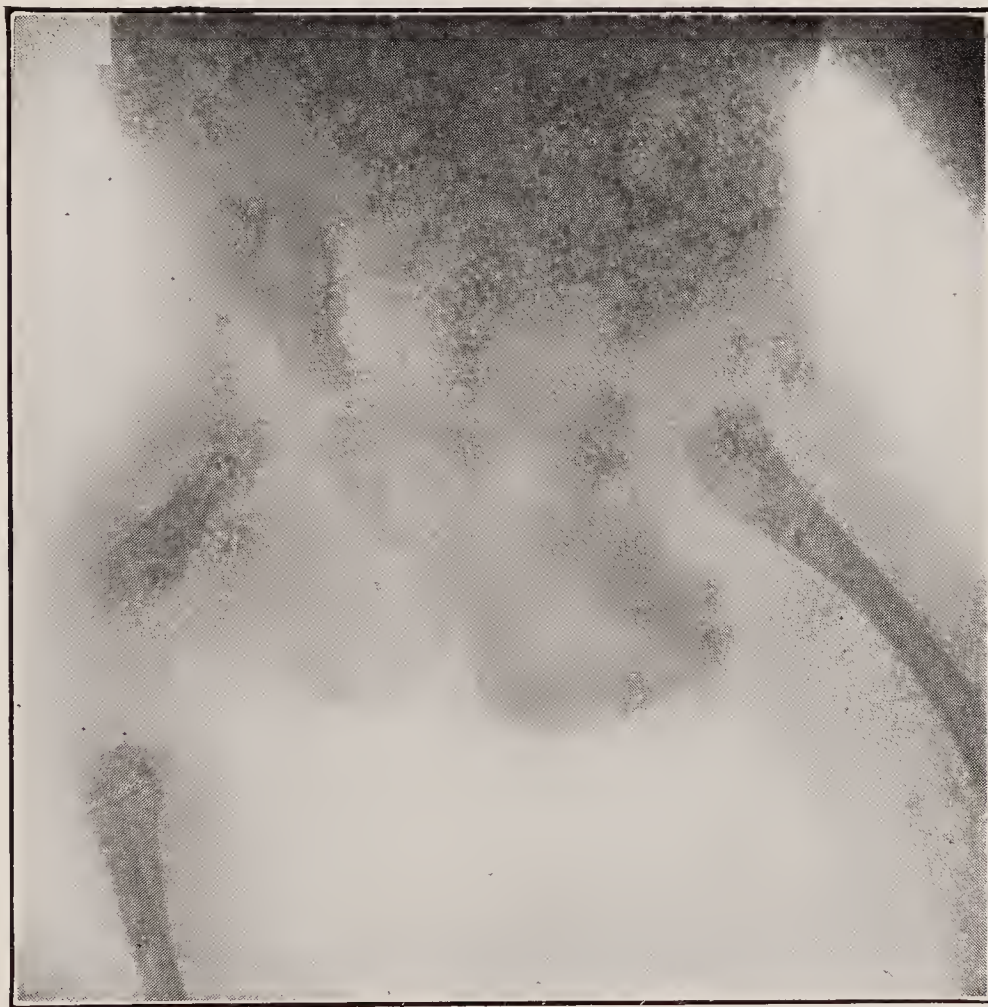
X-ray of congenital defect of femur; same patient as Fig. 584.
